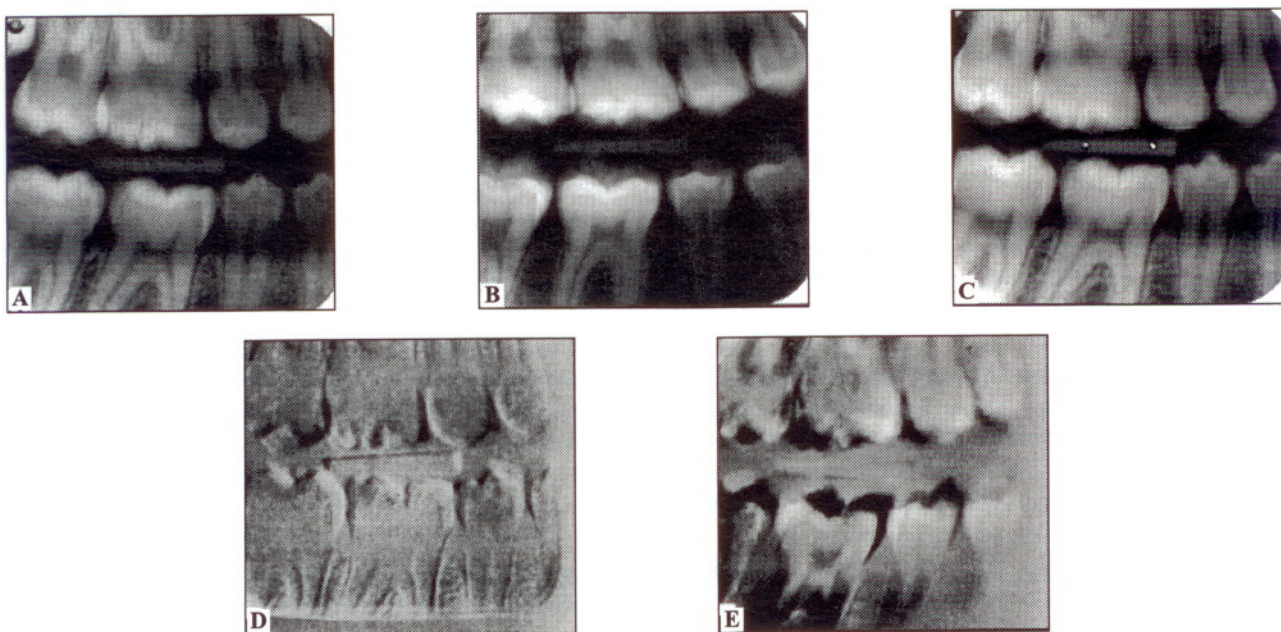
Radiographs from the same (a+c) and two different (b+c) individuals without fillings and the resulting subtraction images [d(ac) and e(bc)].
